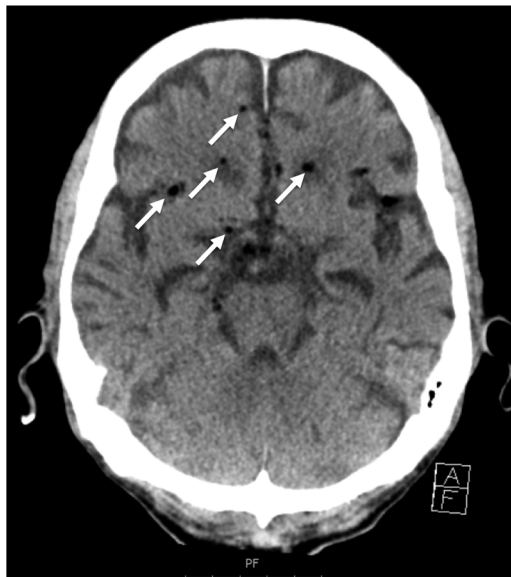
Axial non-contrast CT showing multiple low-density (minus 42 Hounsfield units) abnormalities (arrowed) in the frontal and temporal lobes, and in the parasellar region.
